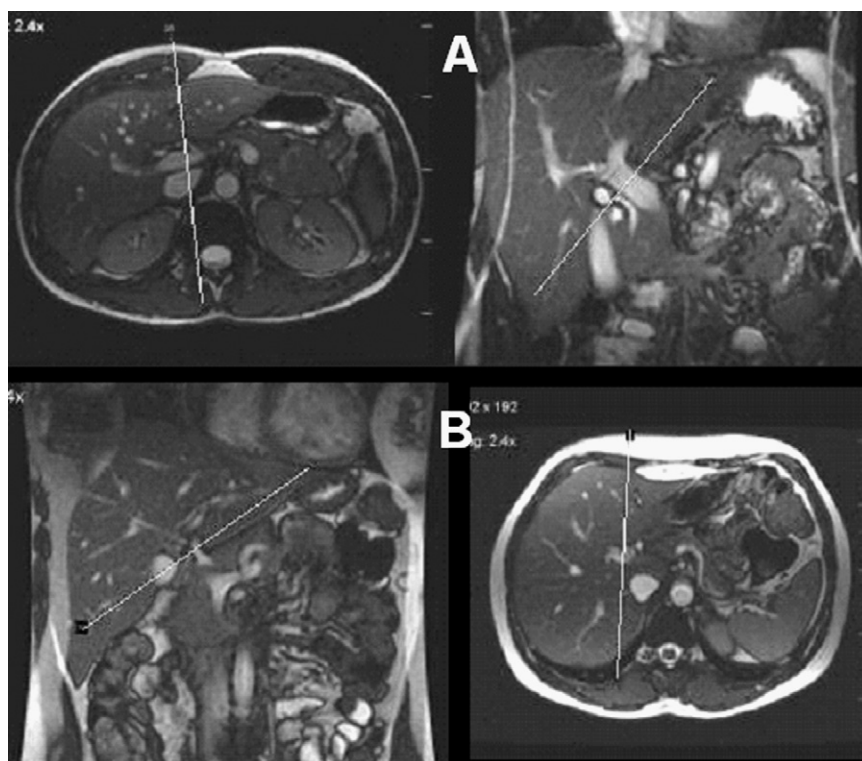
Axial and coronal fast imaging employing steady-state acquisition (FIESTA; GE Medical Systems) localizer MR image of (A) portal vein and (B) proper hepatic artery; (apnea duration near 20 s). Plane sections have been set perpendicularly to the vessels' axis.
